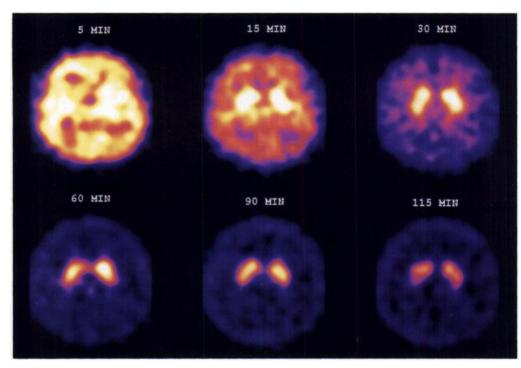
Activity distribution of <sup>123</sup>I-IPT after injection of 6.96 mCi (257.52 MBq) into a 49-yr-old female, normal control. Acquisitions were obtained for 5 min each with a triple-headed SPECT camera over 2 hr and reoriented so that the AC-PC line corresponded to the transaxial axis of the data set. Left BG-to-OCC ratios were 2.72, 4.15, 5.23 and 5.43 at 30, 60, 90 and 115 min, respectively. Right BG-to-OCC ratios were 2.54, 3.76, 5.11 and 5.16 at 30, 60, 90 and 115 min, respectively.
